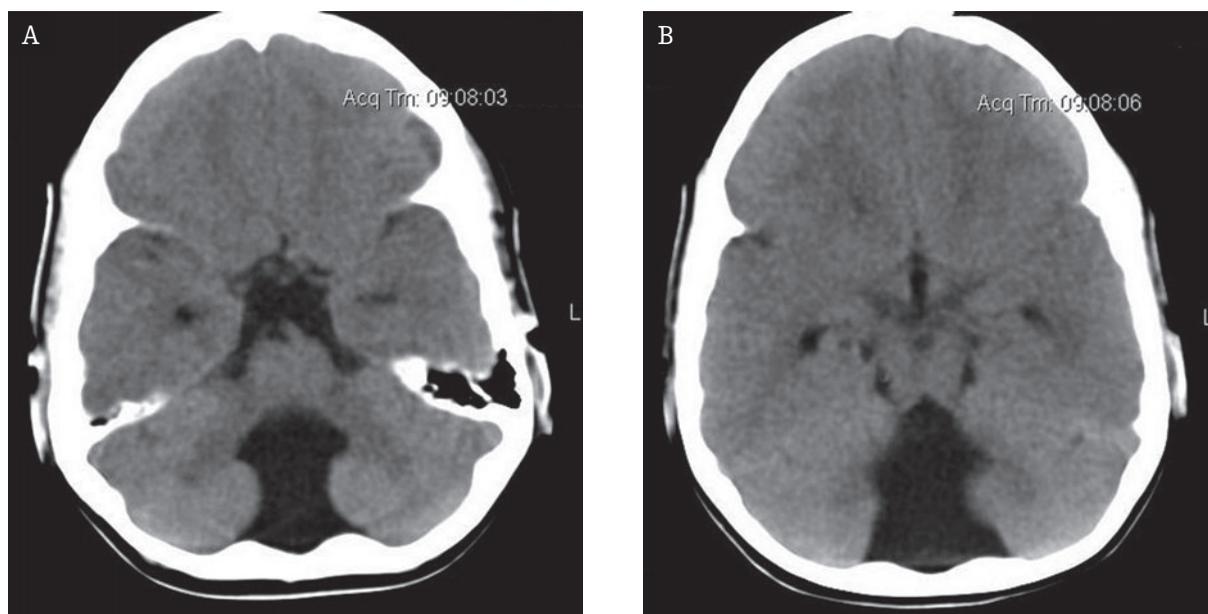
Dandy-Walker variant (DWV). On CT axial scans (A, B) hypoplasia of the cerebellar vermis (absence) is well seen. The fourth ventricle is moderately enlarged and the posterior fossa is only slightly increased in size.
